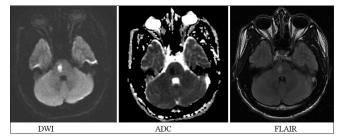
Magnetic resonance imaging image noting the absence of basilar artery flow void consistent with short segment occlusion and absent left vertebral artery flow void concerning for occlusion. Acute infarction demonstrated within right paramedian pons within pontine perforator territory
